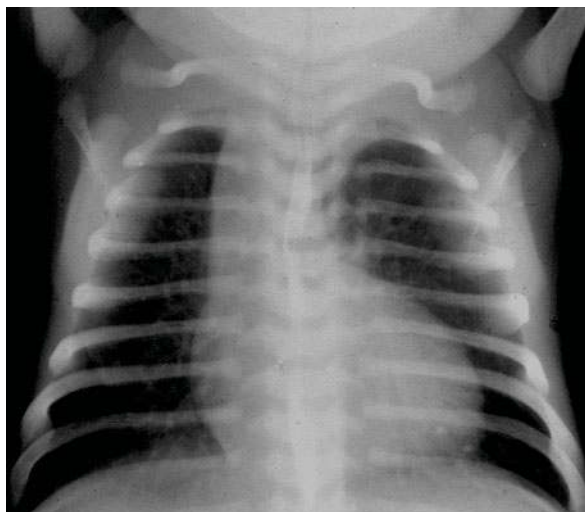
A 2-month-old boy with transposition of the great arteries. Chest radiograph shows narrow superior mediastinum and the egg-like appearance of the heart
